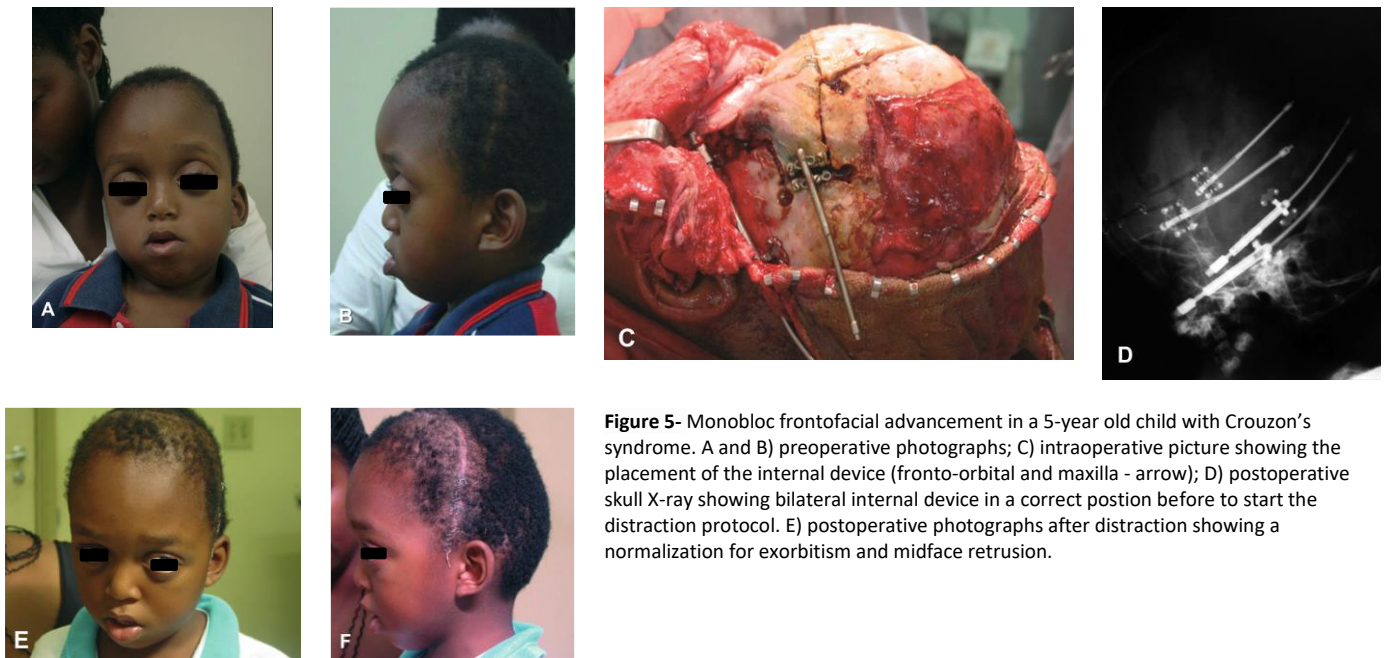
Monobloc frontofacial advancement in a 5-year old child with Crouzon's syndrome. A and B) preoperative photographs; C) intraoperative picture showing the placement of the internal device (fronto-orbital and maxilla - arrow); D) postoperative skull X-ray showing bilateral internal device in a correct position before to start the distraction protocol. E) postoperative photographs after distraction showing a normalization for exorbitism and midface retrusion.
